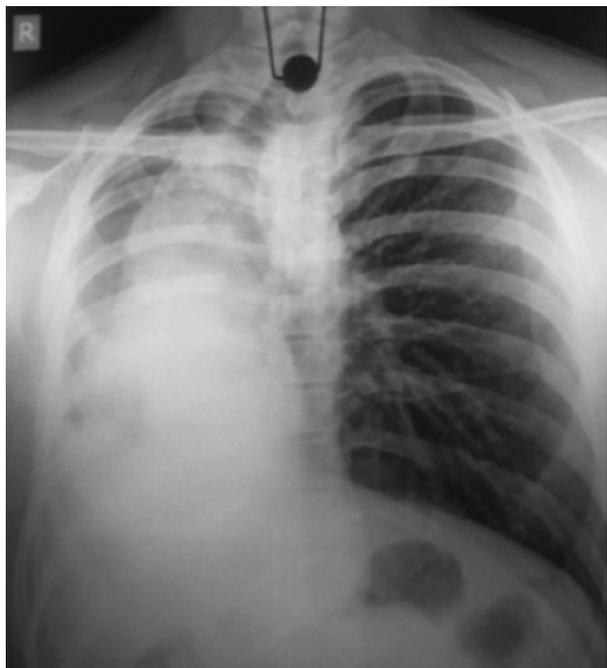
Chest Xray showing collapsed right middle and lower lobes with cutoff in right main bronchus and compensatory hyperinflation of the left lung.
